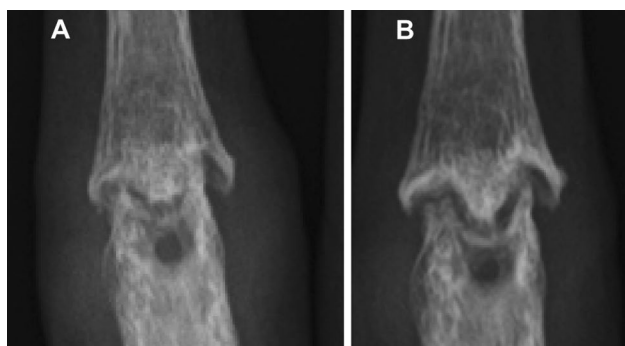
A case showing radiological repair despite inadequate response to a tumor necrosis factor- α inhibitor. A 52-year-old female suffering from active rheumatoid arthritis had been treated with IFX and MTX since October 2008. Although she did not show an adequate response to IFX therapy without improvement of disease activity, dramatic repair of the proximal interphalangeal (PIP) joint of her right middle finger was observed in May 2009. Roentgenogram of the PIP joints of the right middle finger in October 2008 (a) and May 2009 (b). IFX infliximab, MTX methotrexate
